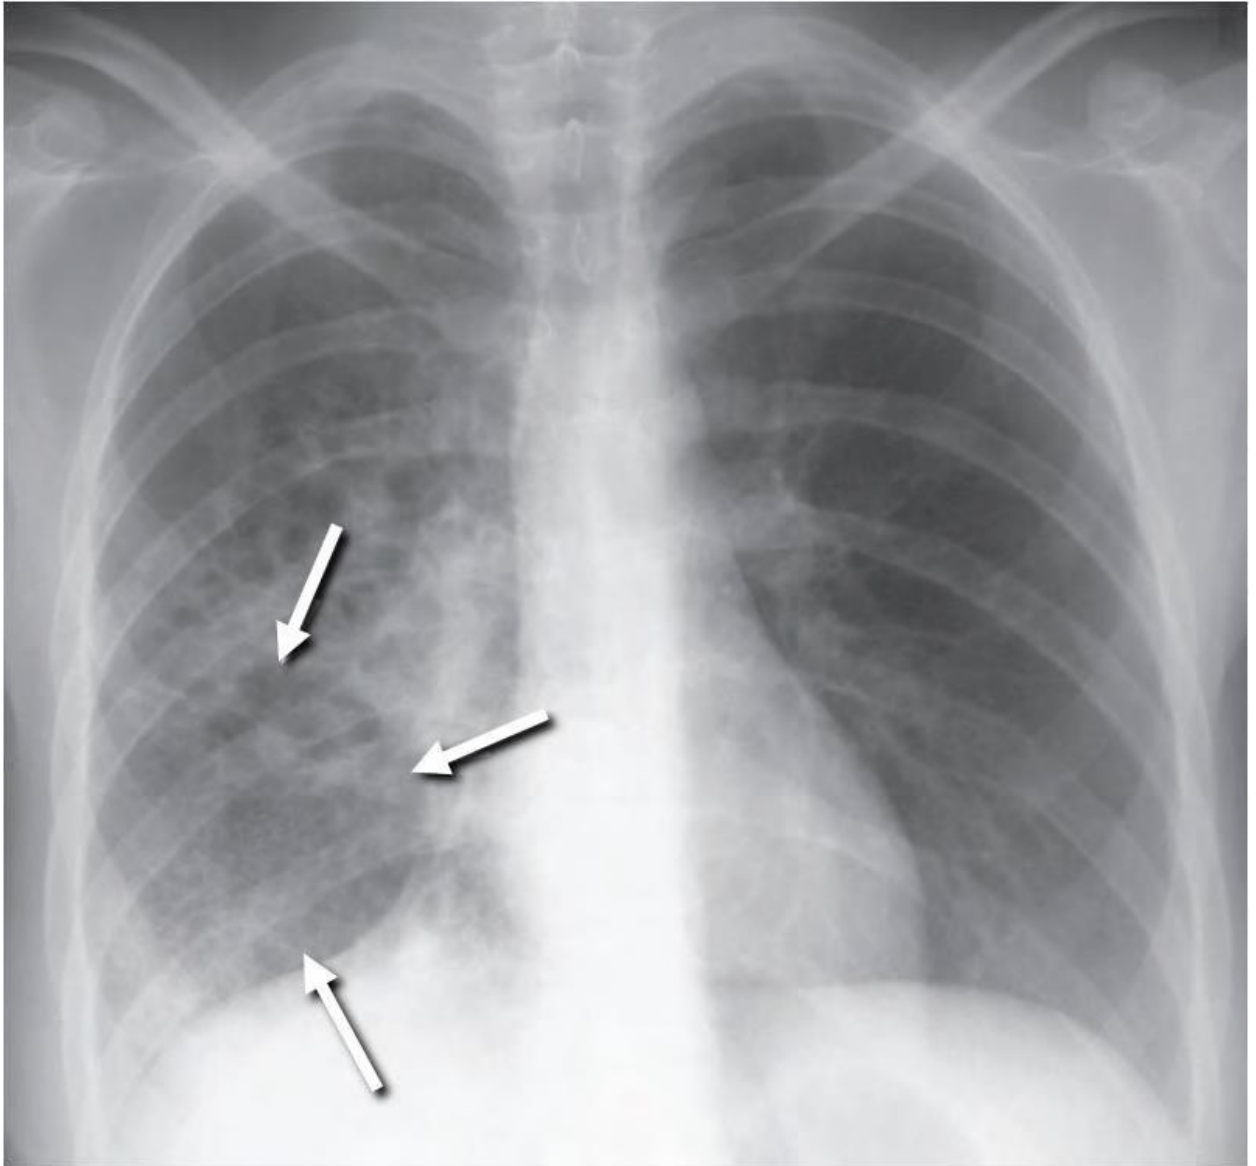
Chest radiograph with lower lobe cavity (Core Curriculum on Tuberculosis, 2013).
